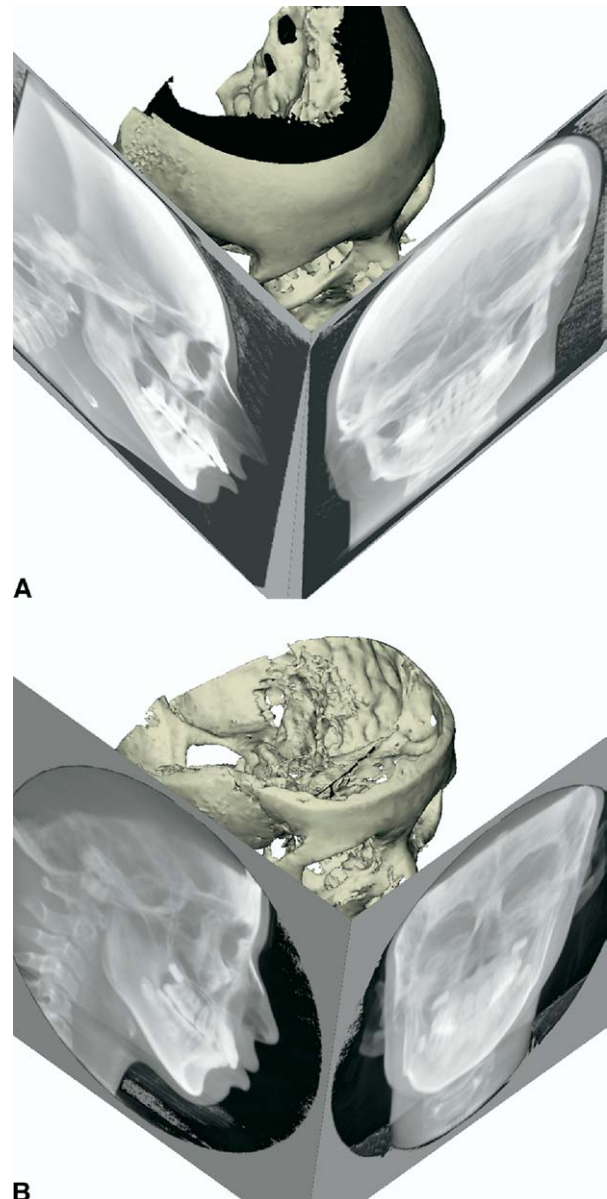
Virtual lateral and frontal cephalograms linked to 3D hard-tissue surface representation of skull: A, i-CAT and B, Hitachi CBCT.
